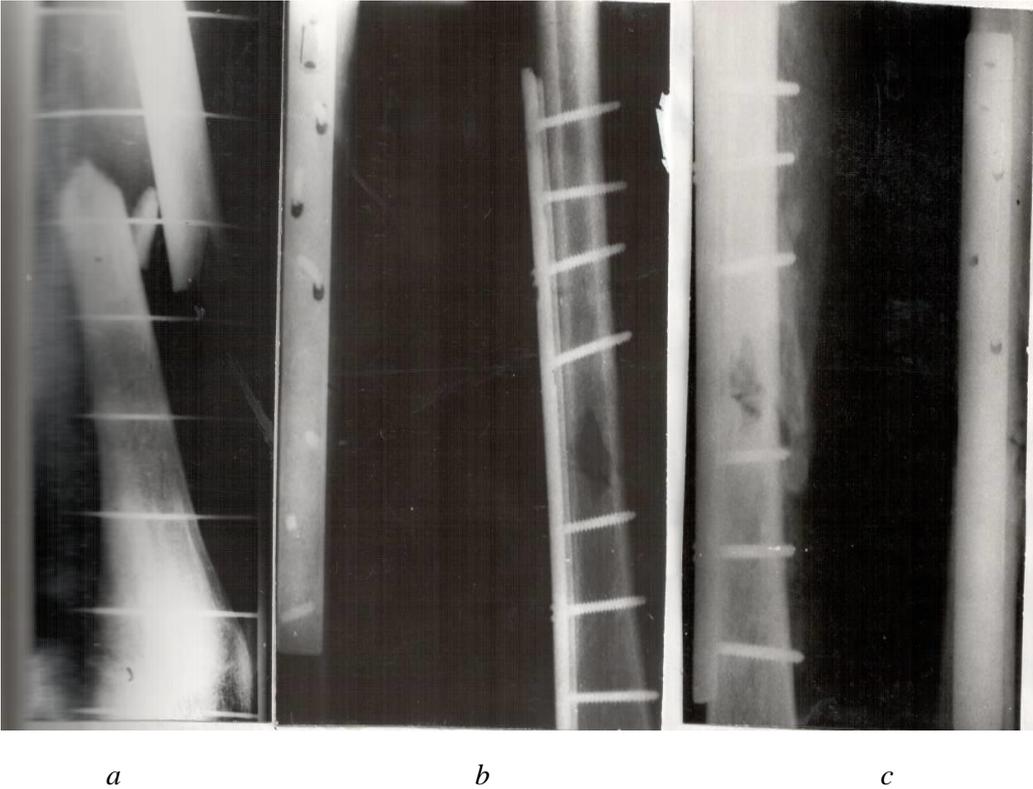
Radiography images of patient to K. MP - comminuted fracture of the right femur (a). Fixation of bone fragments with extramedullary plate and 2 additional screws (b). Fracture consolidation (c), slight periosteal layers.*
